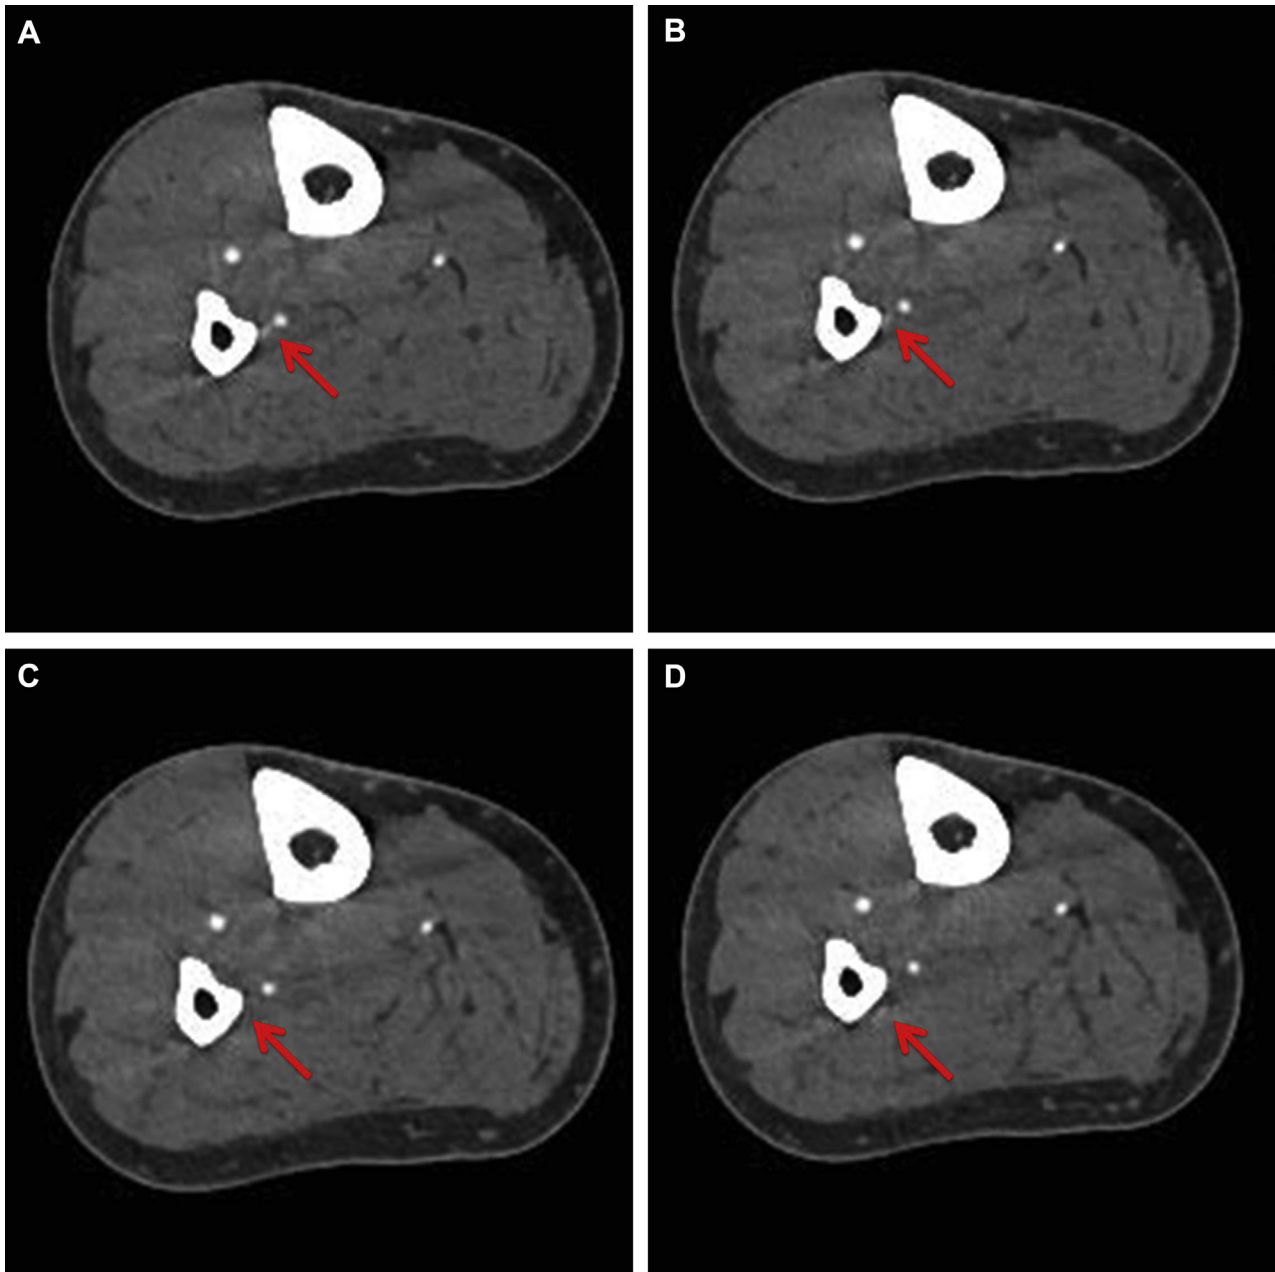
Axial slices from computed tomographic angiography data of the right lower extremity depicting a cutaneous perforator takeoff from the peroneal artery. A-H, Proceeding from proximal to distal, the red arrow delineates the course of the septocutaneous perforator from its takeoff from the peroneal artery to its termination in the skin of the lateral leg.
